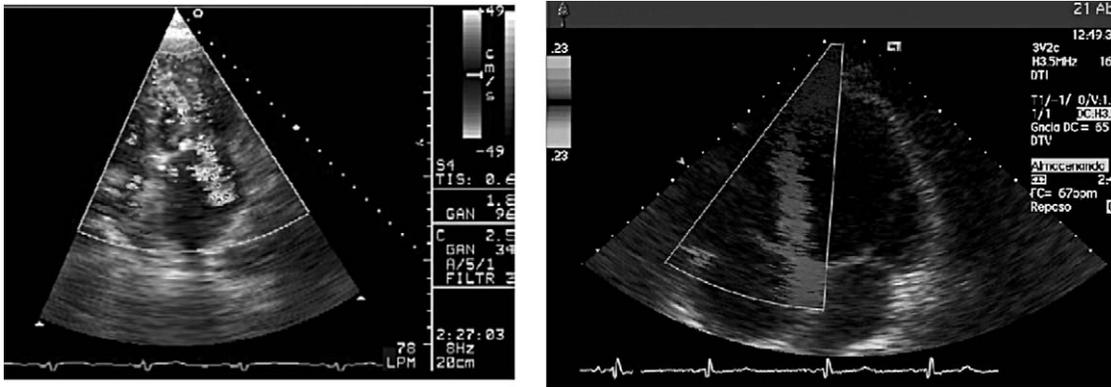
Left.* Color Doppler image of a mild to moderate mitral regurgitation. The image shows an abnormal turbulent jet from the left ventricle into the left atrium systole. Image courtesy of Hospital Dr. Negrín (Gran Canaria, Spain). *Right.* Tissue Doppler image of a four-chamber view of a healthy subject during systole. Image courtesy of Hospital G. U. Gregorio Marañón (Madrid, Spain).
